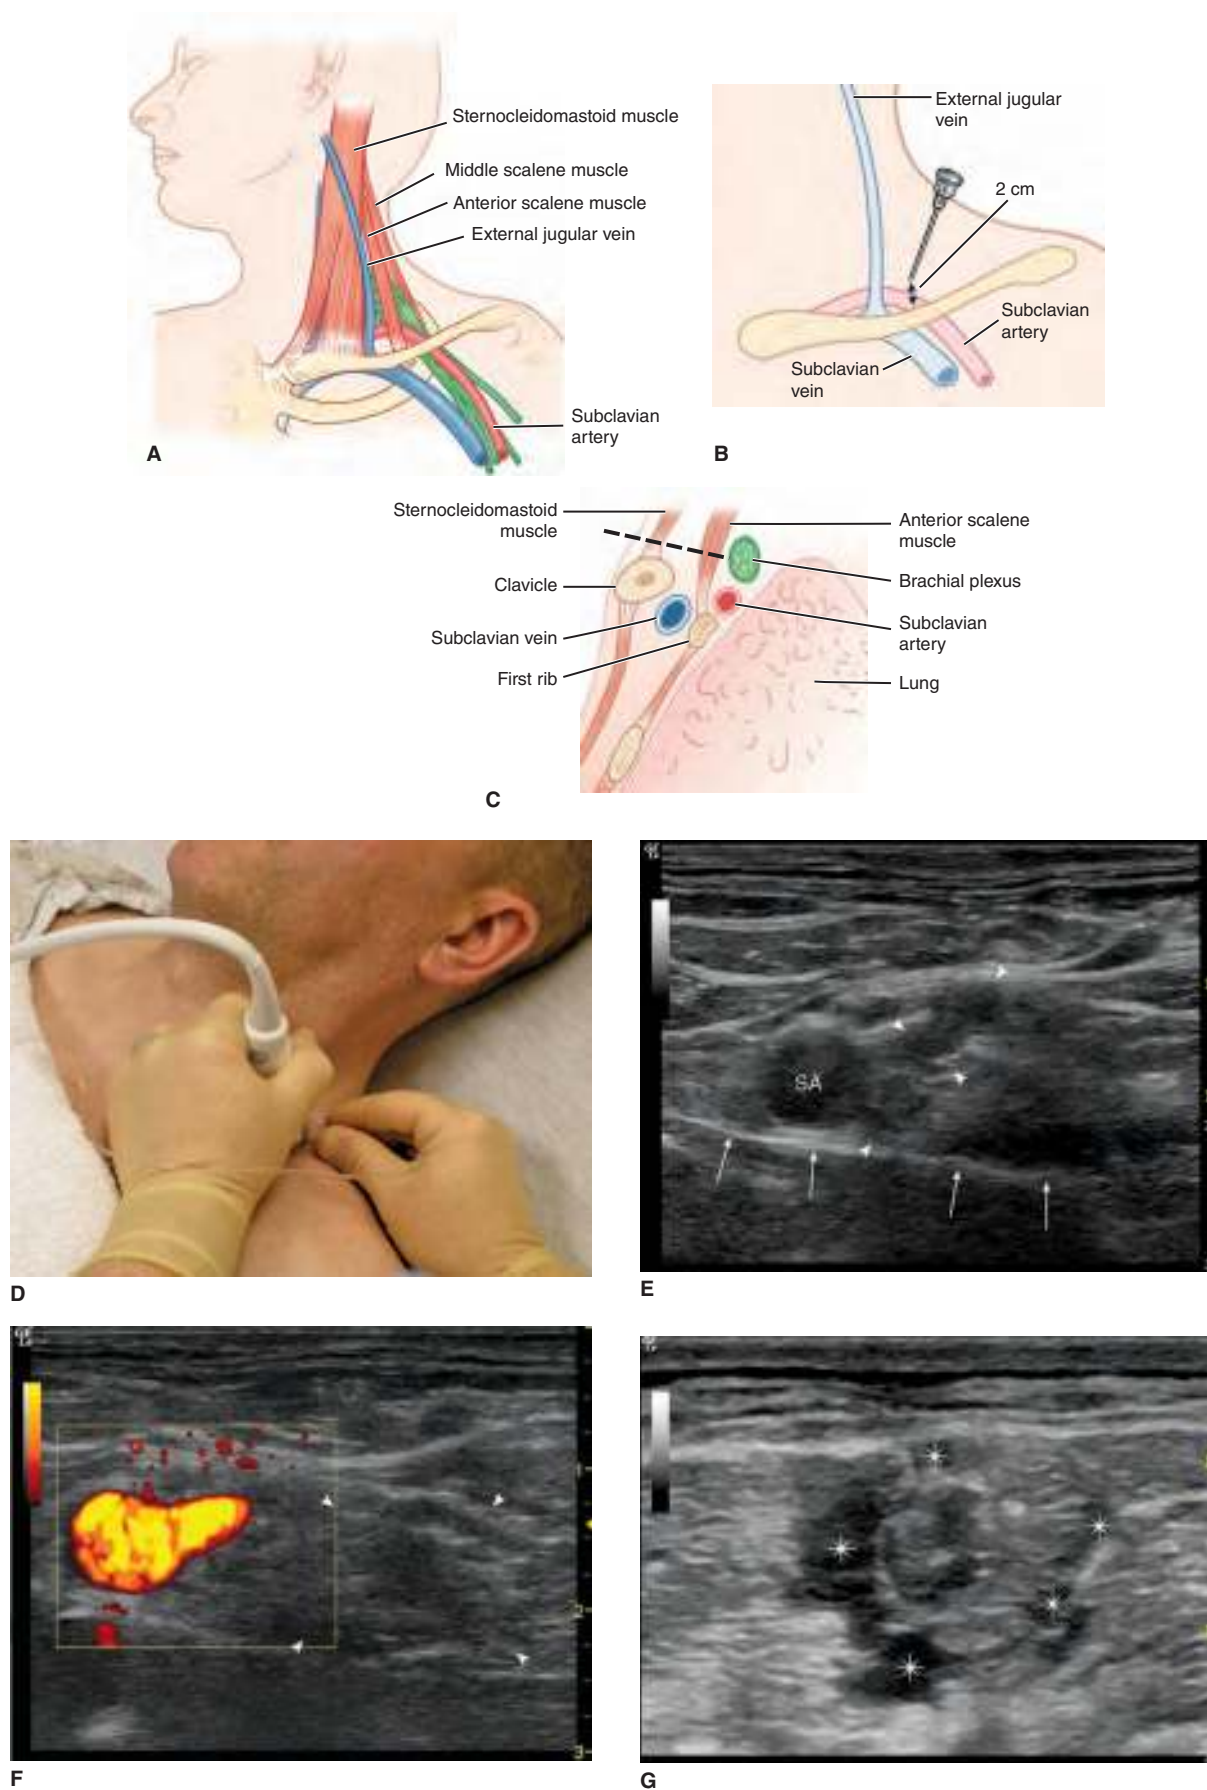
The supraclavicular approach to the brachial plexus block. A. The course of the brachial plexus. B. The needle is inserted perpendicular to the skin and 2 cm superior to the middle of the clavicle. C. Sagittal section demonstrating the trajectory of the needle (*dotted line*). D. US transducer and needle placement. E. The supraclavicular brachial plexus (*arrowheads*) is adjacent to the subclavian artery (SA). The first rib is denoted by the *arrows*. F. Color Doppler of the supraclavicular brachial plexus (*arrowheads*). The subclavian artery and a branch are visible in color. G. The “donut sign.” Local anesthetic solution (*) surrounds the nerve bundles.
